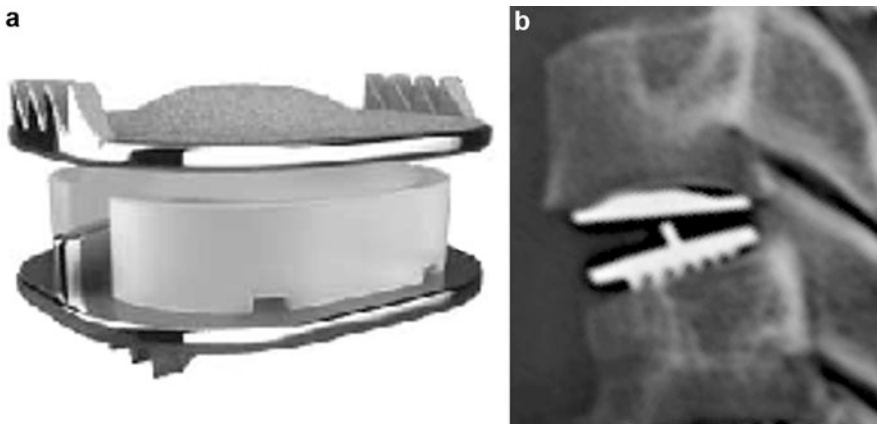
Mobi-C cervical disc: (a) device; (b) lateral X-ray after implantation
